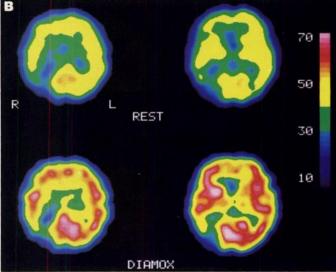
Representative MRI and SPECT images in a patient of cortical WS infarct (Patient 24). (A) MRI shows cortical WS infarct between the MCA and posterior cerebral artery of the right side. (B) SPECT images reveal preserved resting CBF and acetazolamide reactivity, except for the infarcted area (%INC = 46.4%).
